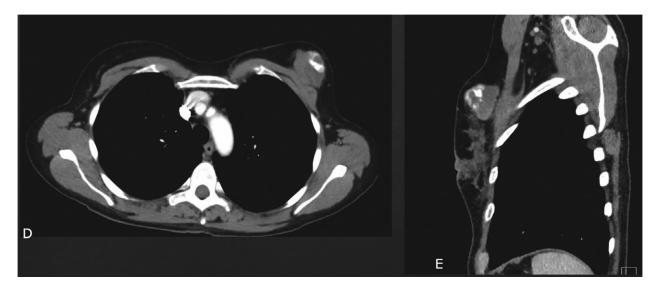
CT axial (D) and sagittal (E) images of the chest show the left breast mass with calcifications of dense bone density.
